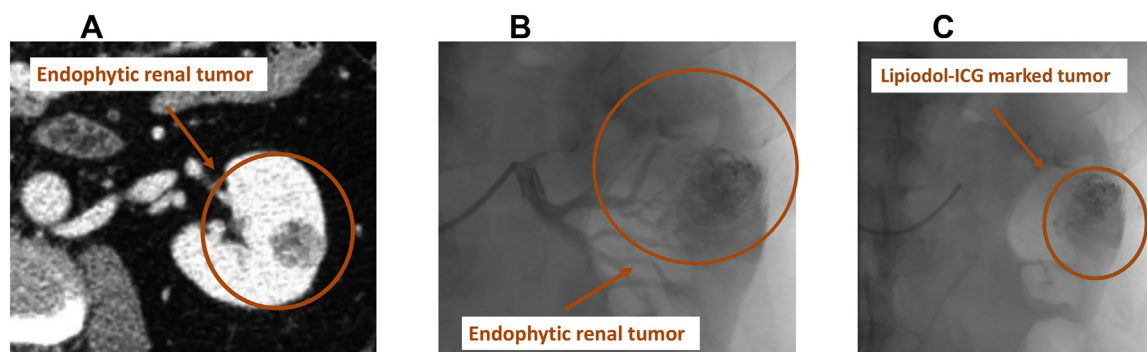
(A) Preoperative CT scan, showing a left-side 2.8 cm totally endophytic renal tumor. (B) Contrast-enhanced angiographic appearance of the mass. (C) Final appearance of lipiodol-ICG–marked tumor. CT = computed tomography; ICG = indocyanine green.
